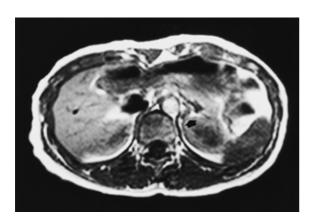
MRI of the adrenal gland. A T 1-weighted image demonstrates an adenoma (arrow).
